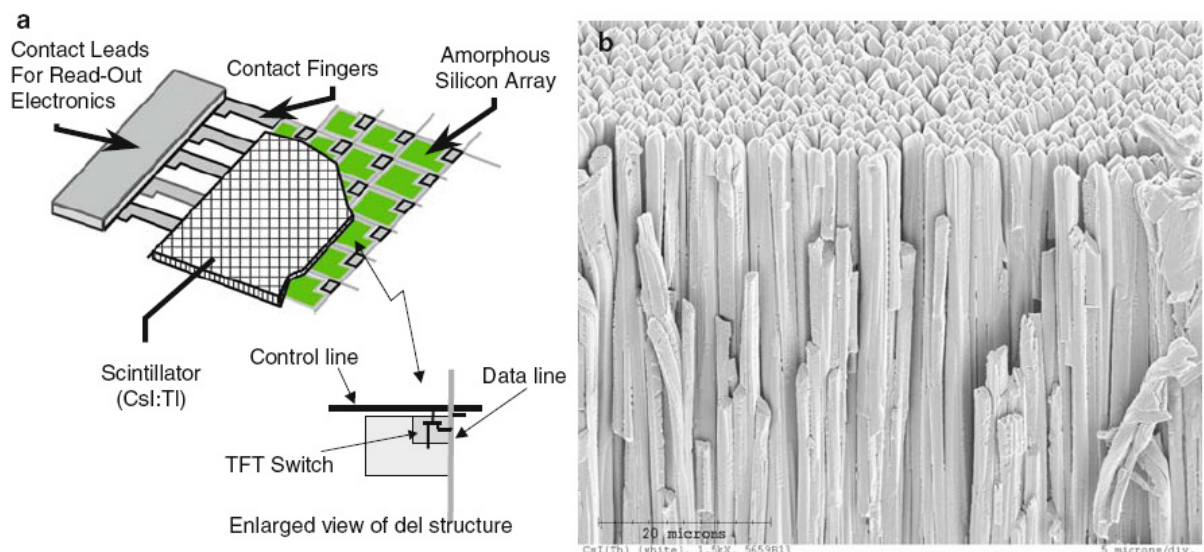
Flat panel detector with CsI(Tl) absorber. (a) Detector with photodiode array. TFT readout element is shown in inset. (b) Structure of CsI:Tl needle phosphor (Reprinted from Enhanced a-Si/CsI-based flat-panel X-ray detector for mammography [30, 32]).
